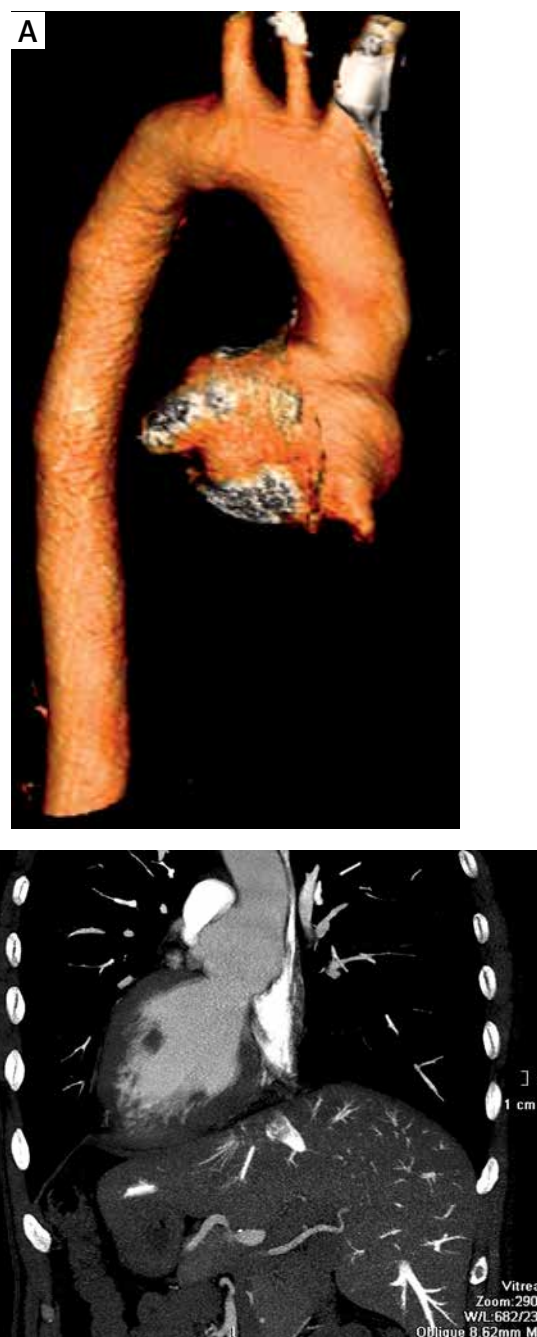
Preoperative aortic annulus/root aneurysm associated with dilated left main coronary artery visualized by three-dimensional computed tomography (CT) using (A) a volume rendering technique and (B) multiplanar reformation CT, sagittal oblique view
